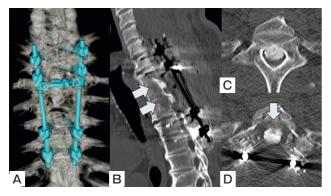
Postoperative CT. A, 3D CT; B, Mid-sagittal reconstruction CT; C, Preoperative axial CT at T1; D, Postoperative axial CT at T1 showing the floating OPLL and the completely decompressed spinal cord.
